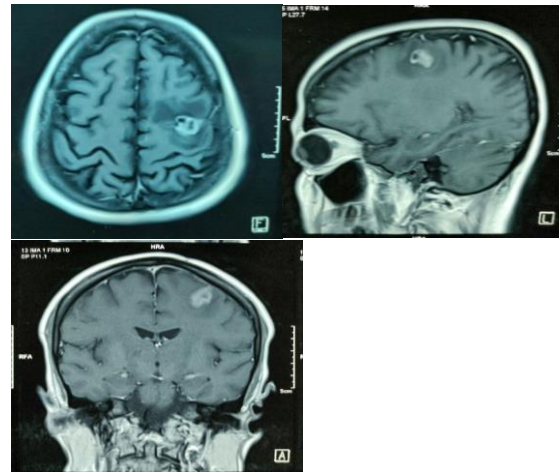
MRI of brain with contrast showing left frontal metastatic SOL with peri lesional edema with no other significant abnormality (before radiotherapy).
